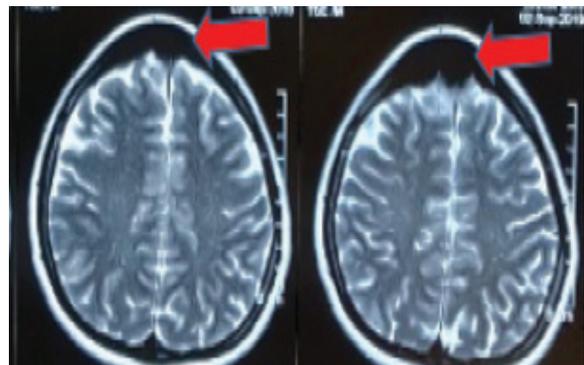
Magnetic resonance imaging T2W axial images showing expansile hypointense lesion in diploic space of fronto-parietal bone
